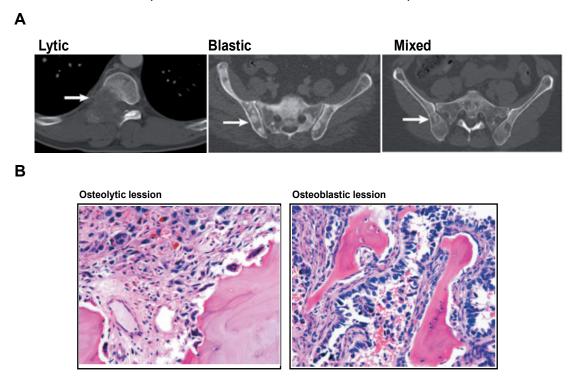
Clinical presentations of bone metastases. (A) Computerized tomography (CT) scans that show the different types of bone lesions: a lytic metastasis present in a
